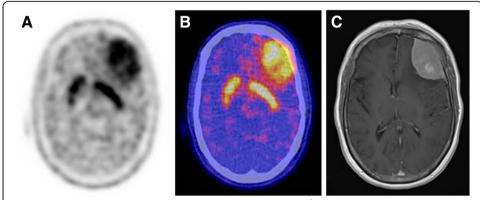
The meningeoma on the left frontal region showed elevated ¹⁸F-FDOPA uptake (a, b), confirmed on MRI (c). Physiological ¹⁸F-FDOPA uptake in the striatum
